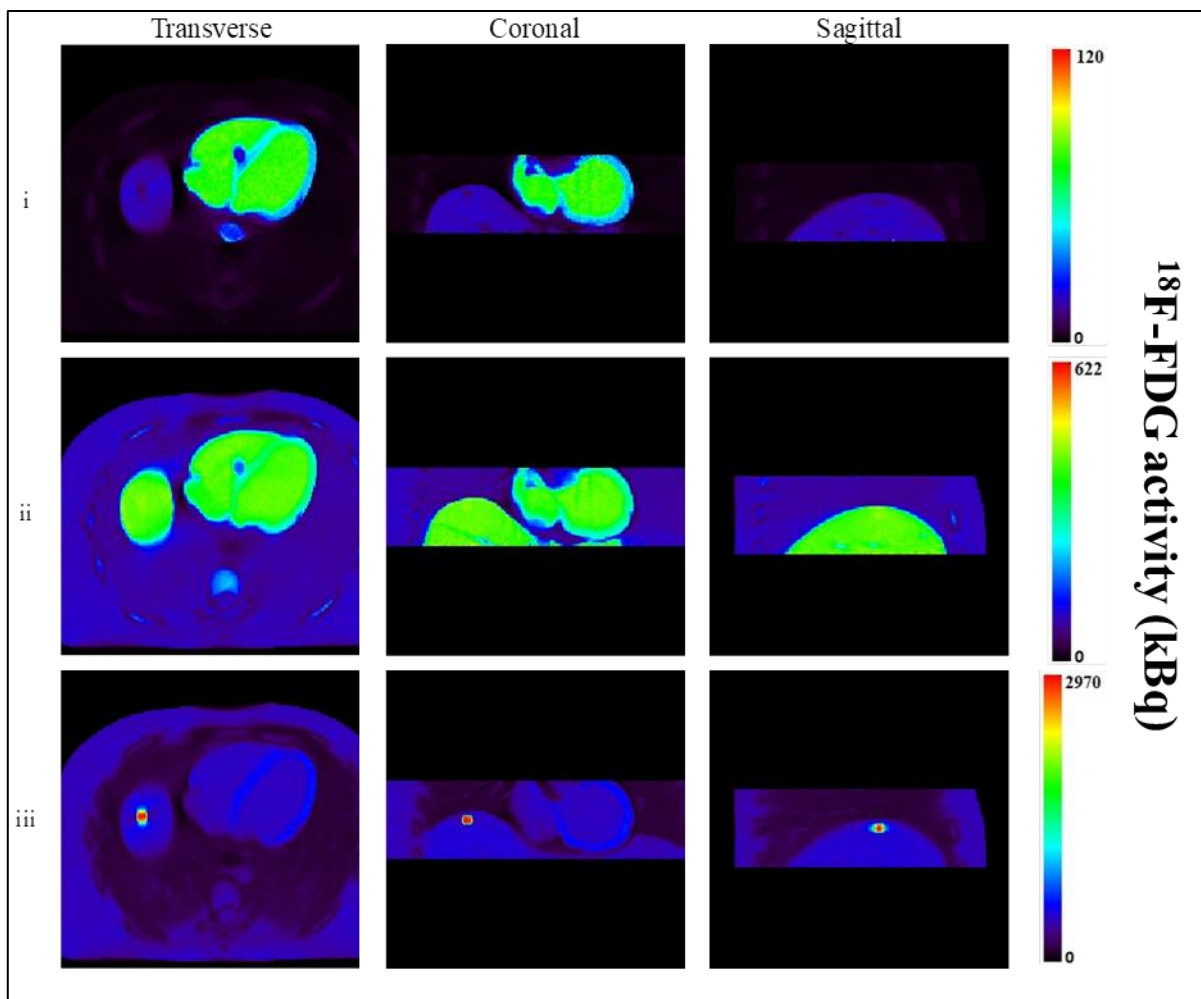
Transverse, coronal and sagittal reconstructed ^{18}F -FDG PET images taken at 3 different time points corresponding to i = frame 1, ii = frame 17 and iii = frame 28.
